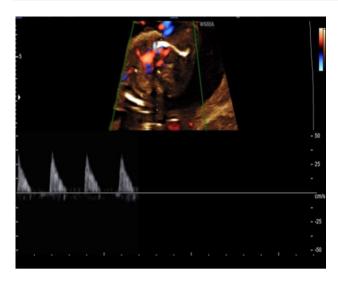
Pulse Doppler on retrotracheal vessel shows arterial waveform thus excluding hemiazygous vein and confirming ARSA
